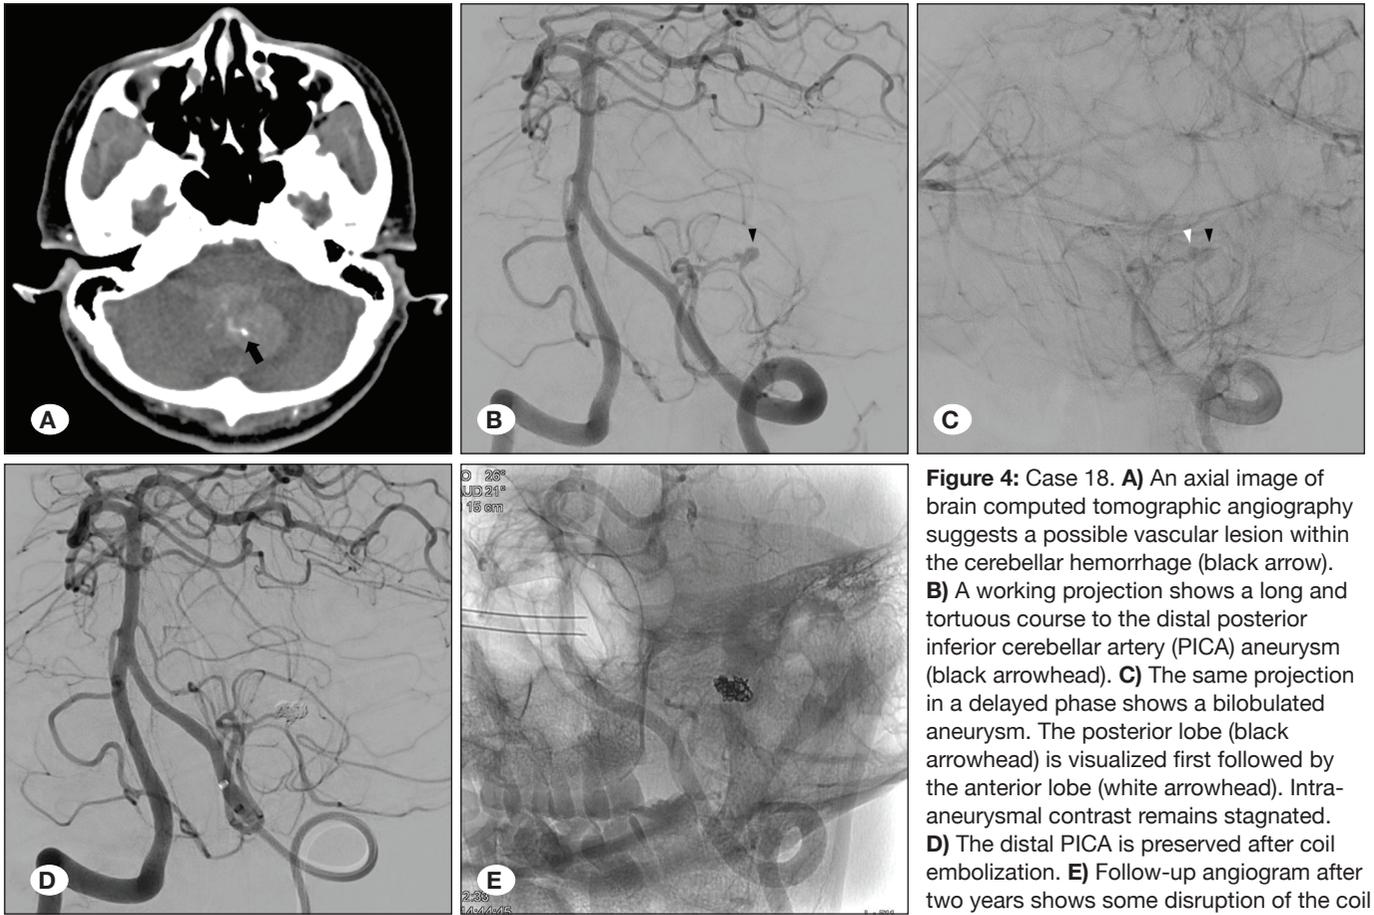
Case 18. A) An axial image of brain computed tomographic angiography suggests a possible vascular lesion within the cerebellar hemorrhage (black arrow). B) A working projection shows a long and tortuous course to the distal posterior inferior cerebellar artery (PICA) aneurysm (black arrowhead). C) The same projection in a delayed phase shows a bilobulated aneurysm. The posterior lobe (black arrowhead) is visualized first followed by the anterior lobe (white arrowhead). Intra-aneurysmal contrast remains stagnated. D) The distal PICA is preserved after coil embolization. E) Follow-up angiogram after two years shows some disruption of the coil structure but no recurrences are seen.
